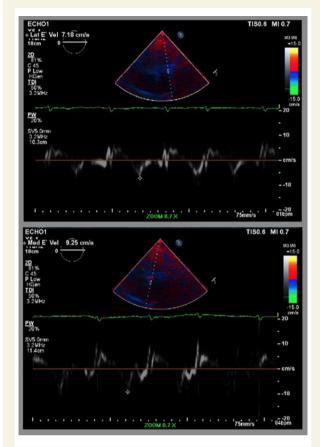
Transthoracic echocardiogram tissue Doppler showing medial and lateral annular velocities.
